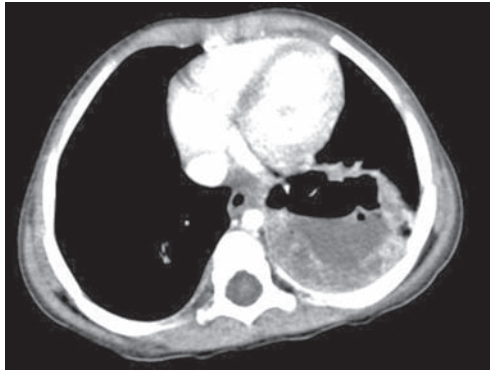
CT scan in another patient showing left basal lung abscess
